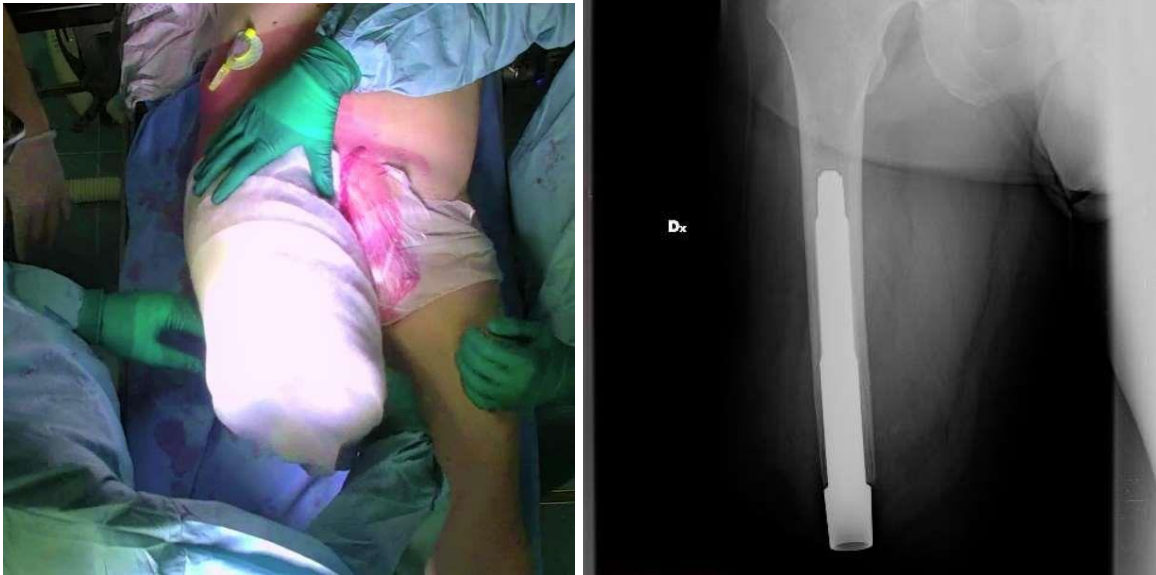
The compression bandage (left) and postoperative radiographic control (right)
